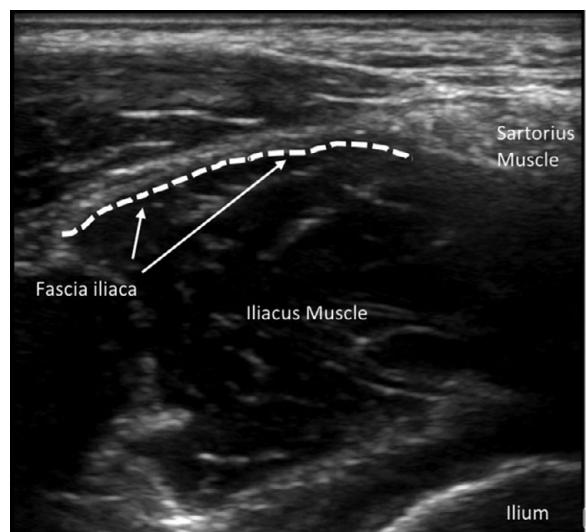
Ultrasound anatomy of the fascia iliaca plane
